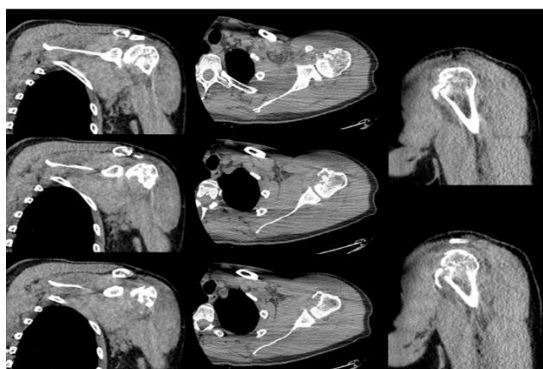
CT imaging of the left shoulder showing a comminuted displaced lesser tuberosity fracture. There is extension of the fracture line towards the greater tuberosity and into the anatomic neck
